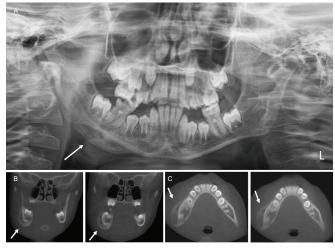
(A) The panoramic radiograph shows an "onion skin" appearance on the outer cortical surface in the right mandibular region. (B) Sagittal section view of bone proliferation on CBCT, (C) Axial section view.
